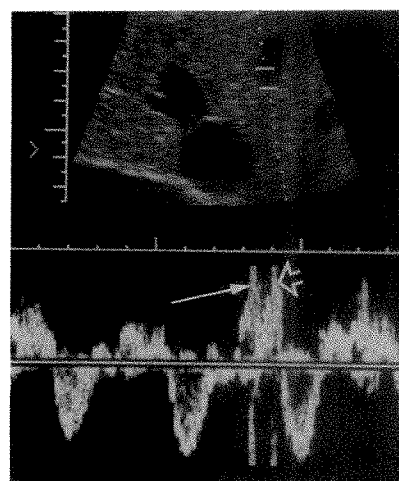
Hepatic vein duplex Doppler sonogram in aortic-right atrial fistula. Note very large retrograde systolic wave (solid arrow), which is combining with a very large retrograde v wave (open arrow). Note also large antegrade diastolic wave (>60 cm/sec).
